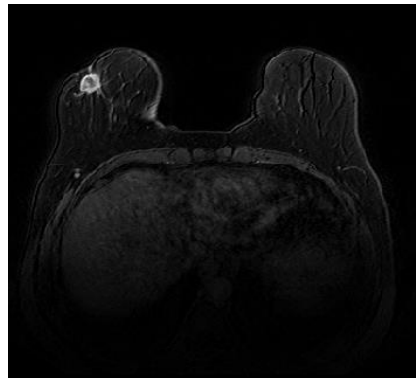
MRI visualization using *iSeg* after selecting “CT weight”, “Bone”, and “crop”, where it is visible that the tumor region is brighter than the surrounding breast tissues.
